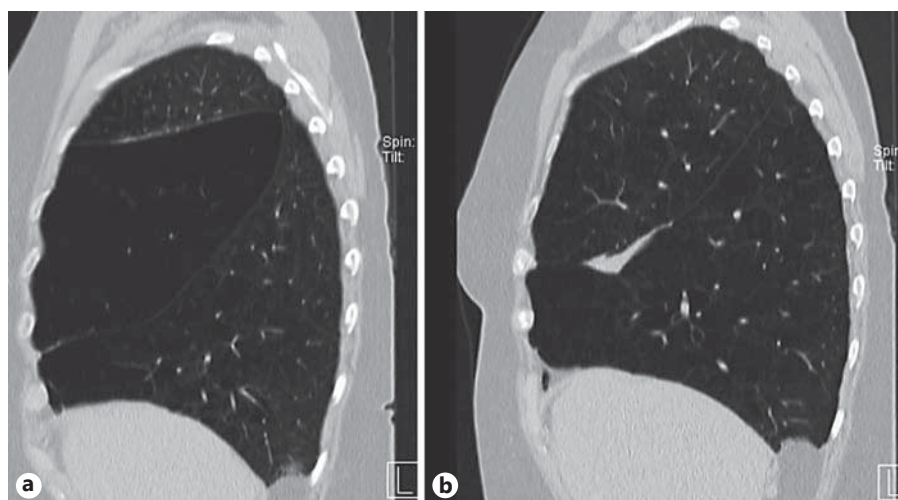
Patient 8. a Sagittal CT scan of the right lung, showing the hyperinflated middle lobe. b After ELVR: same view, now an atelectatic middle lobe.
